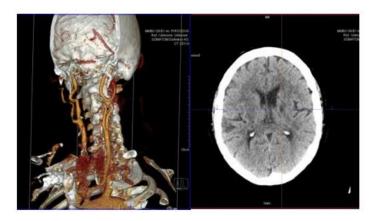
Brain CT and CT angiography of a patient with left ICA stenosis. CT – computer tomography. ICA – internal carotid artery
